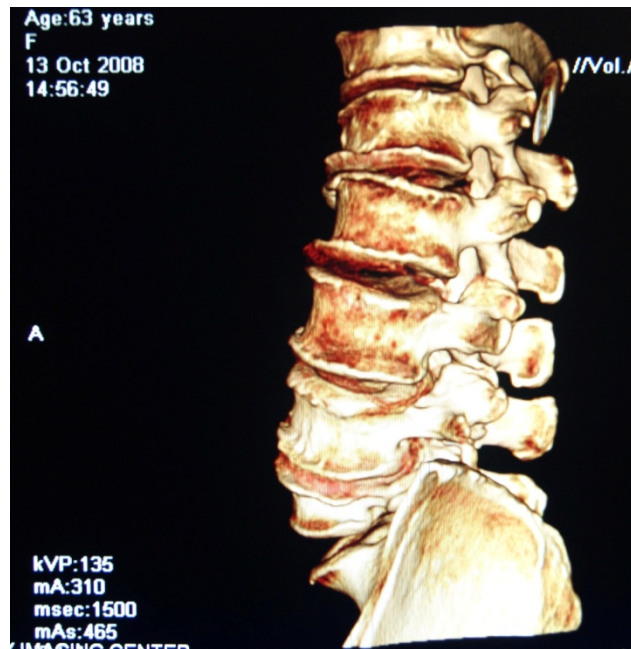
is a lateral view 3D CT image
